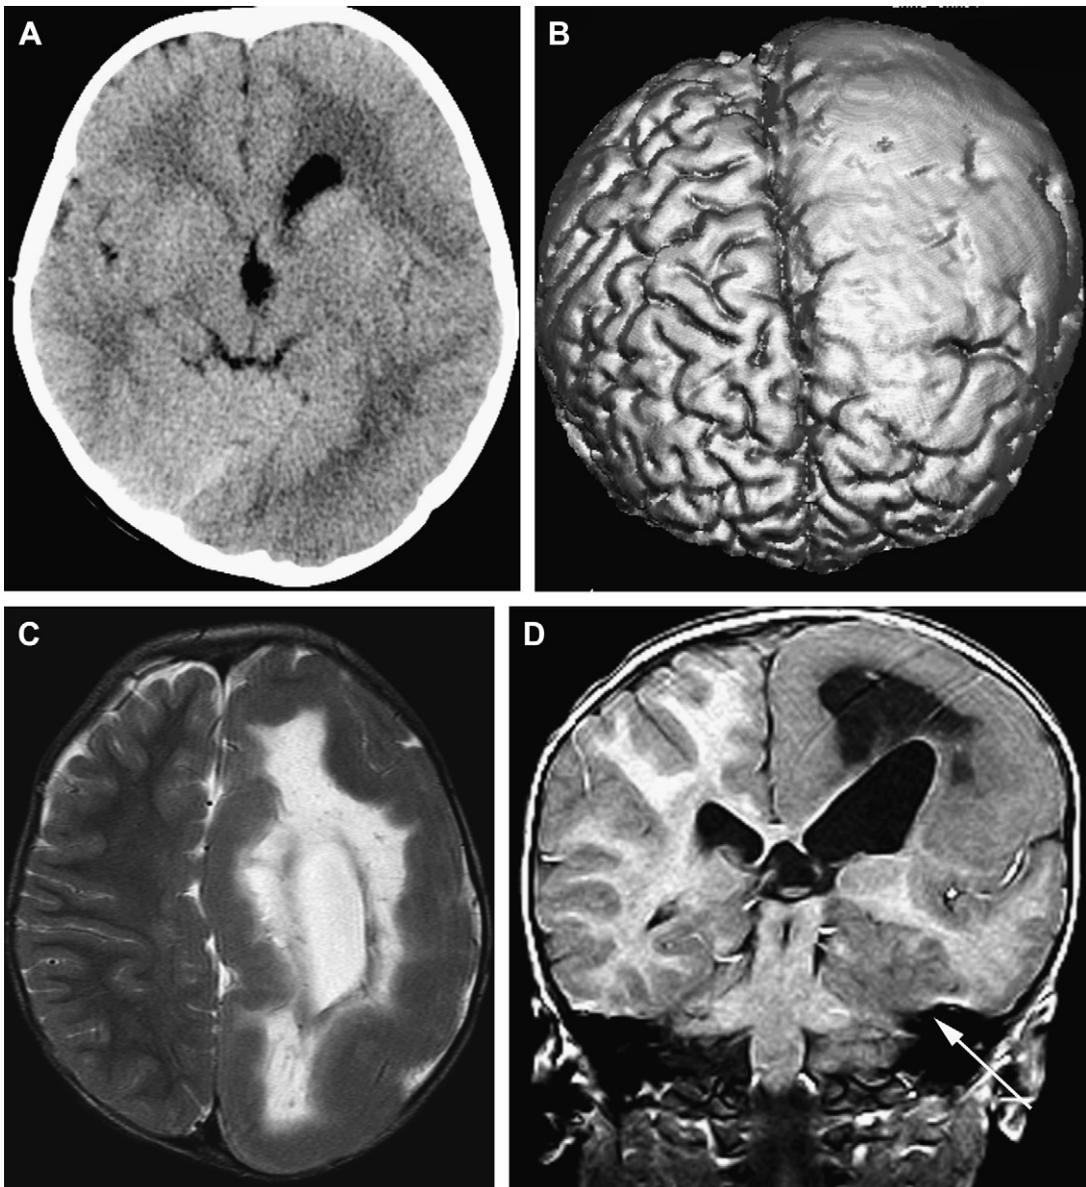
Left HME. (A) CT image demonstrates a huge dysplastic left hemisphere with large ventricle and prominent occipital lobe. The posterior falx is dislocated to the right. (B) Tridimensional volume rendering shows the essentially agric portion of the abnormal hemisphere. (C) Axial T2. Diffuse agyria with thick cortex and dysplastic, unmyelinated white matter; note the abnormal appearance of the right hemisphere as well, with straightening of the sulci in the rolandic area. (D) Coronal T1. Massive enlargement of the ventricle; the temporal lobe is relatively spared, but its medial aspect shows massive dysplasia (arrow).
